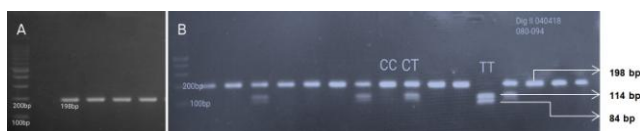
A) Electrophoresis of PCR product showing 1 band (198bp); B) Electrophoresis of Digested PCR Product. CC genotype consists of 1 band (198 bp), CT genotype consists of 3 bands (198 bp, 114 bp, and 84 bp) and TT genotype consists of 2 bands (114 bp and 84 bp). Marker 100 bp on lane 1
